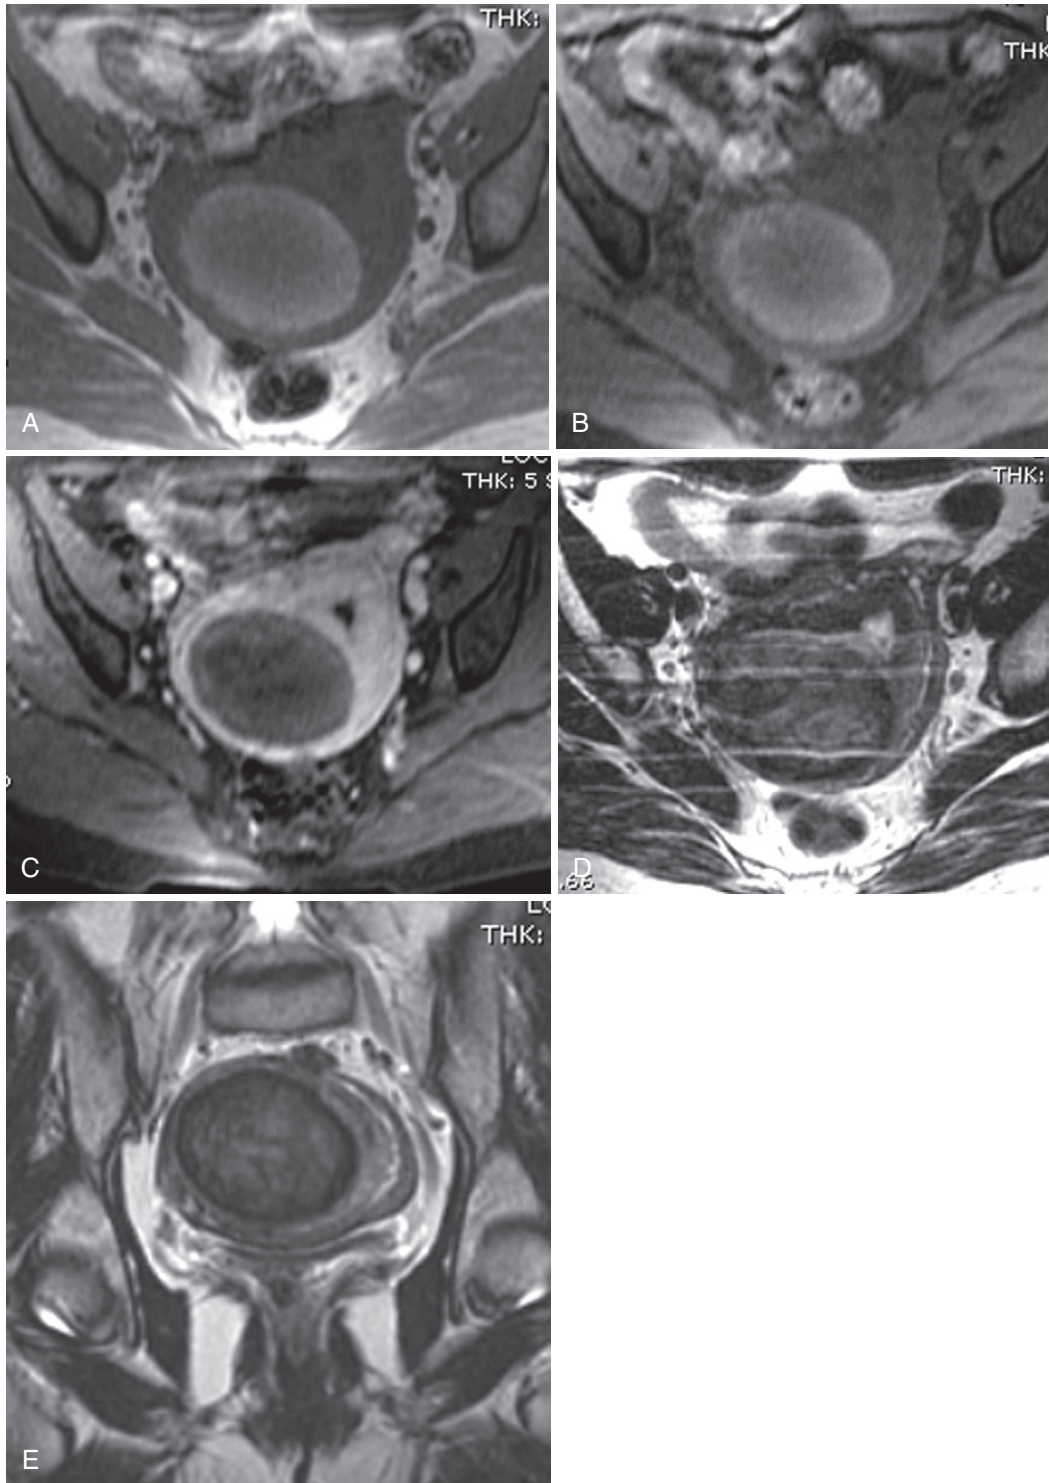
Fibroid with hemorrhagic degeneration. A mostly intramural fibroid with focal submucosal extension hyperintense on a T1-weighted (in-phase) image without fat suppression (A) maintains hyperintensity on the corresponding T1-weighted fat saturated image (B), confirming hemorrhage. C, The absence of enhancement on the postcontrast image confirms degeneration. Axial (D) and coronal (E) T2-weighted images reveal mild relative hyperintensity compared with uncomplicated fibroids.
